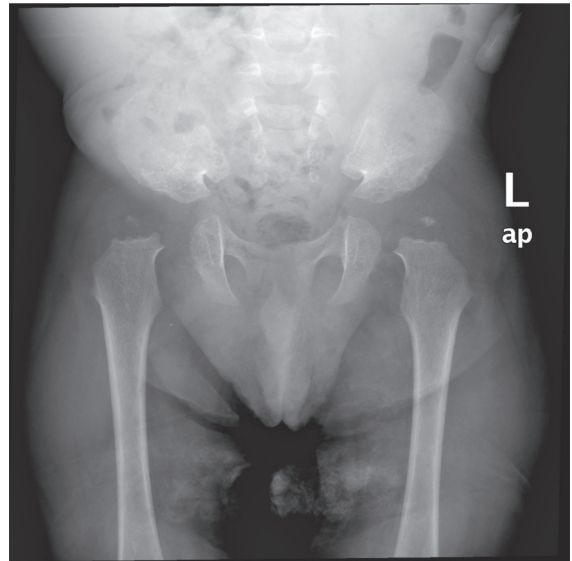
Pelvic radiograph reveals small and displaced capital femoral epiphyses, dysplastic acetabulum and hip subluxation.
